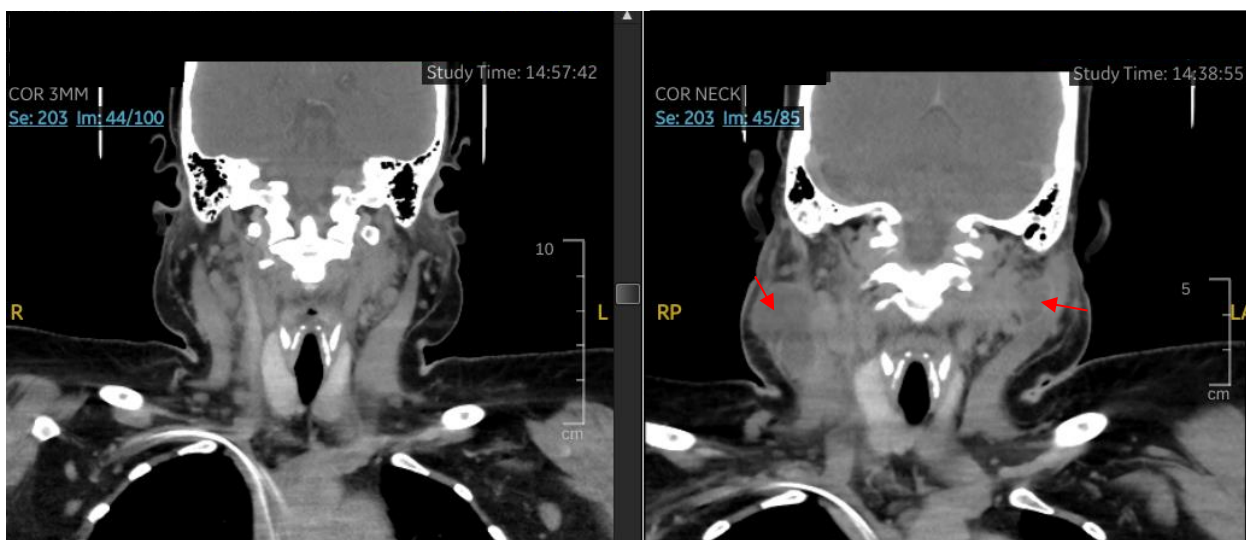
Coronal view CT neck, previously inflamed cervical lymph nodes (left), progressed into suppurative nodes and deep neck abscess (right)
